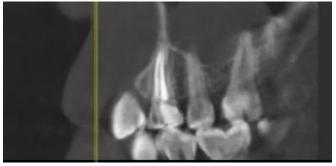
Adequate canal obturation: root filling, confining 0-2mm from the apex of the radiograph and homogenous root. Canal filling, perfect condensation, denied apparent vacuity.
